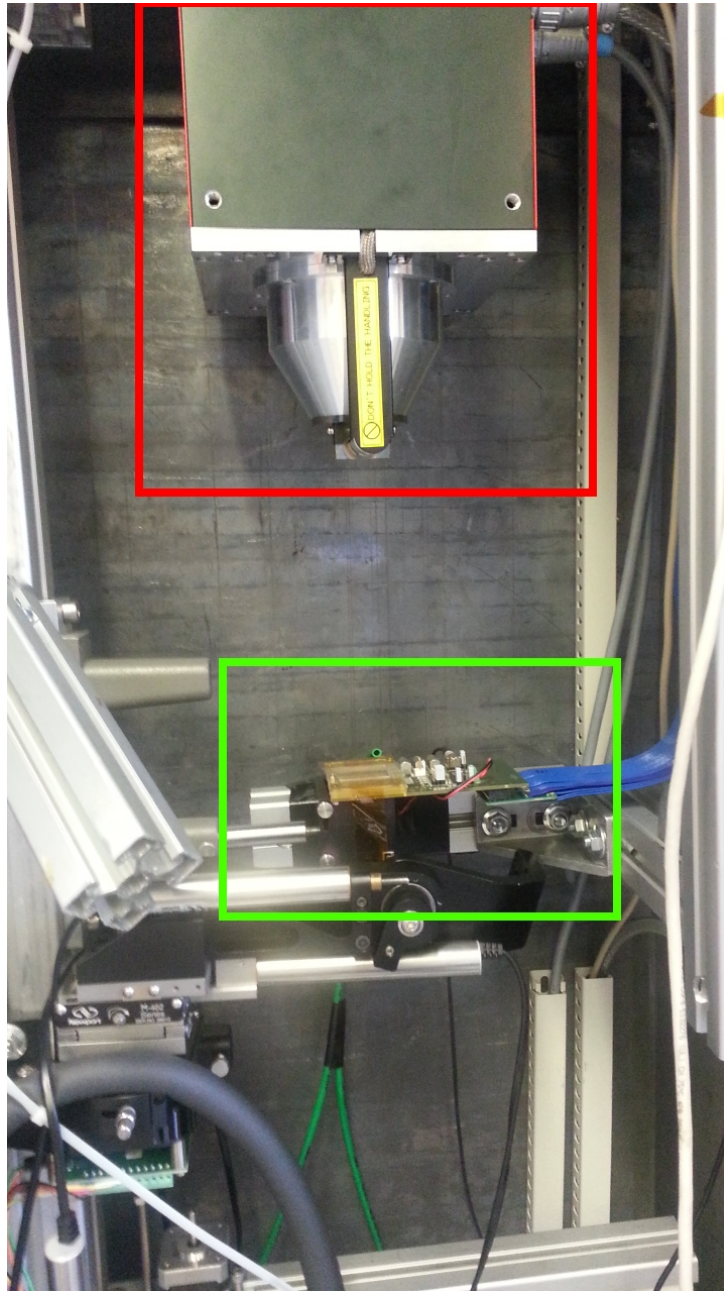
An overview of the experimental setup. We have marked the x-ray tube with a red border, the Medipix3RX is marked with green. The blue cable coming off of the Medipix3RX leads to the SPIDR board which was attached to the wall of the containing x-ray cabinet, next to the x-ray tube.
